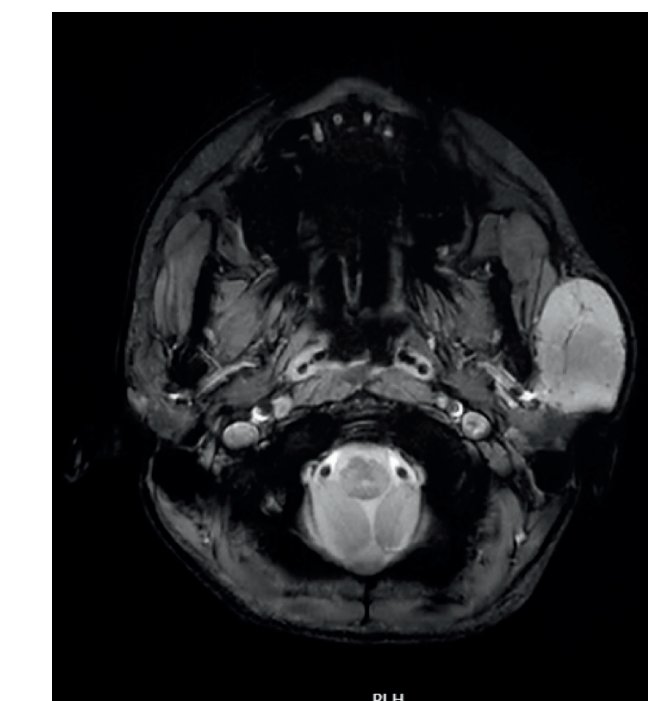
MRI showing hyperintense lesion
